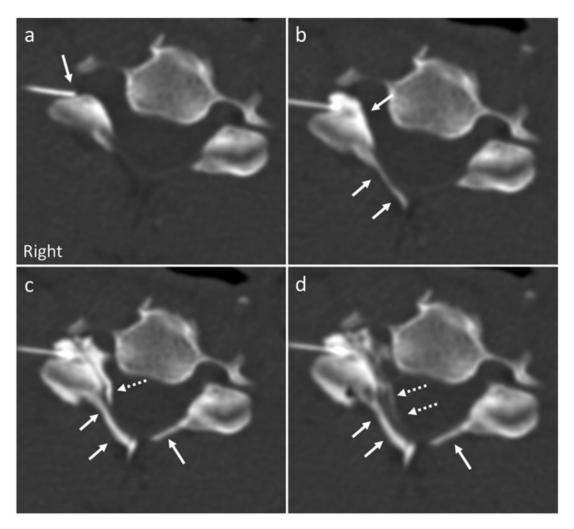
Patient 3. CT-guided right C5–C6 transforaminal epidural steroid injection in a 28-year-old male. Precontrast axial image (a) shows the needle tip in the posterolateral right C5–C6 neural foramen (arrow). After injection of about 2 mL of dilute iohexol 300 mgl/mL, contrast appears to fill the foramen but also clearly flows dorsal to the ligamentum flavum in the retrodural space of Okada (b, arrows), extending into the interspinous region. After repositioning of the needle and additional contrast injection, there was mostly central epidural flow (c, dashed arrow), clearly distinct from the more dorsal retrodural contrast (c, solid arrows). Washout image after dexamethasone injection showed that medication flowed in the epidural space (d, dashed arrows), with unchanged retrodural contrast (d, solid arrows).
